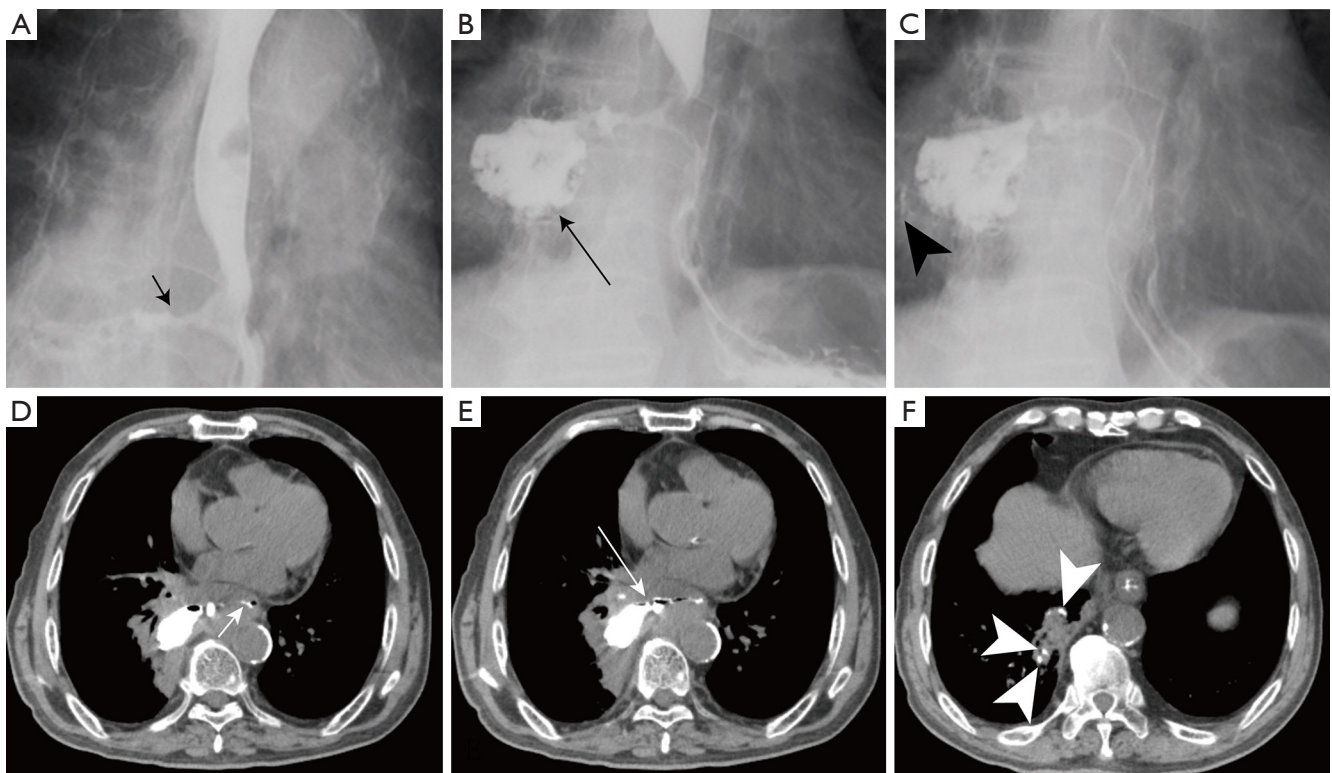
CT and upper gastrointestinal imaging after radiotherapy. (A) Right anterior oblique X-ray shows esophageal sinus tract formation (short black arrow). (B) Mediastinal paranasal sinus cavity is noted in the left anterior oblique image (long black arrow). (C) Radiograph of left anterior oblique indicates a flow of contrast medium into the bronchi of the lower lobe of the right lung (black arrowhead). (D) Axial CT demonstrates the entrance to the esophageal sinus tract (short white arrow). (E) Sinus tract exit is pointed out (long white arrow). (F) The flow of contrast medium into the bronchi of the lower lobe of the right lung is clear on the CT image (white arrowhead). CT, computed tomography.
